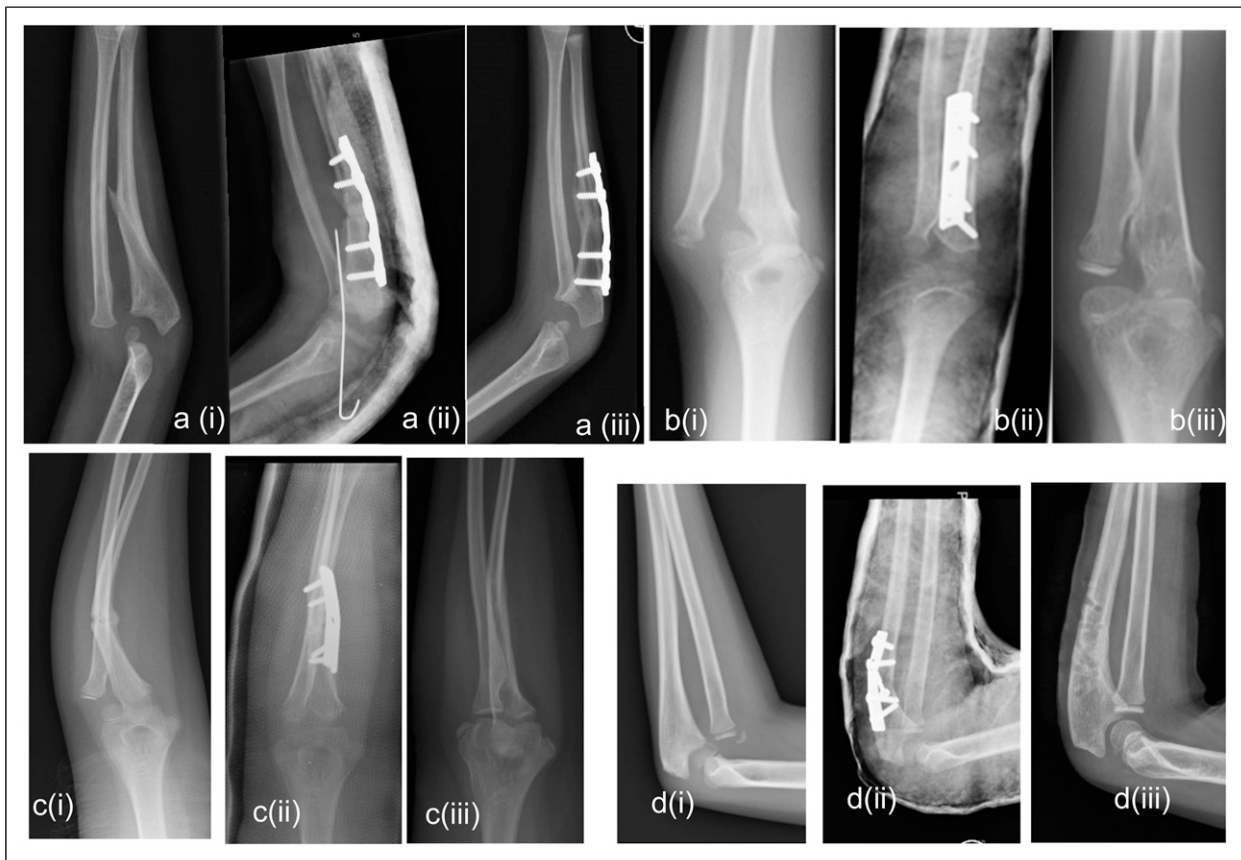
The plain radiograph view of all our patients; patient no1 (a), patient no2(b), patient no3(c) and patient no4(d). The radiograph showed initial radiograph at presentation (i), post operative in POP (ii) and radiograph at latest follow up (iii). Note in radiograph a(ii) presence of radio-capitellar Kirschner wire as the immediate post operative radiograph.
